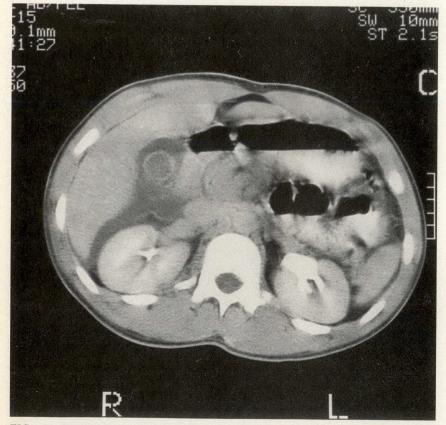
Preoperative computed tomography scan of abdomen demonstrating significant subhepatic and pericholecystic free fluid.
